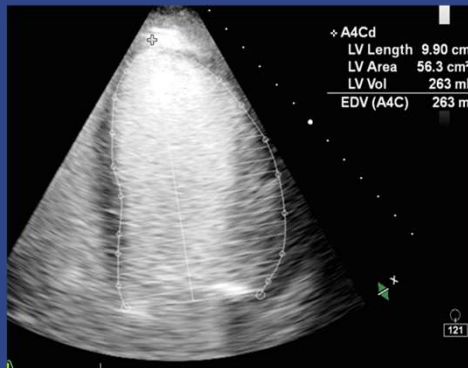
UEA apical four Simpson's end diastolic volume.
